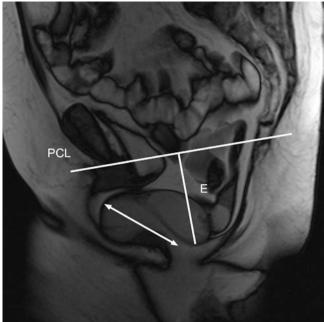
76-year old female patient with an enterocele and anterior rectocele. Midsagittal T2-weighted trueFISP MR image during defecation shows protrusion of a moderate enterocele (5 cm) (E) into the extended perineum leading to compression of the distal rectum resulting in outlet obstruction. The large anterior rectocele shows retention of contrast medium due to compression by the enterocele. The extension of the anterior rectocele is measured as the maximum wall protrusion beyond the expected margin of the normal anterior rectal wall (white arrow). *PCL* pubcoccygeal line, *E* enterocele
